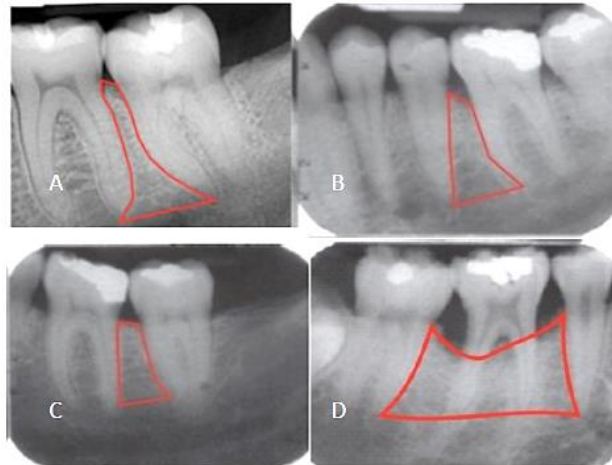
Alveolar bone radiography in: (a) normal; (b,c) chronic periodontitis; (d) aggressive periodontitis (Source: Rahmania., et al. 2019)
